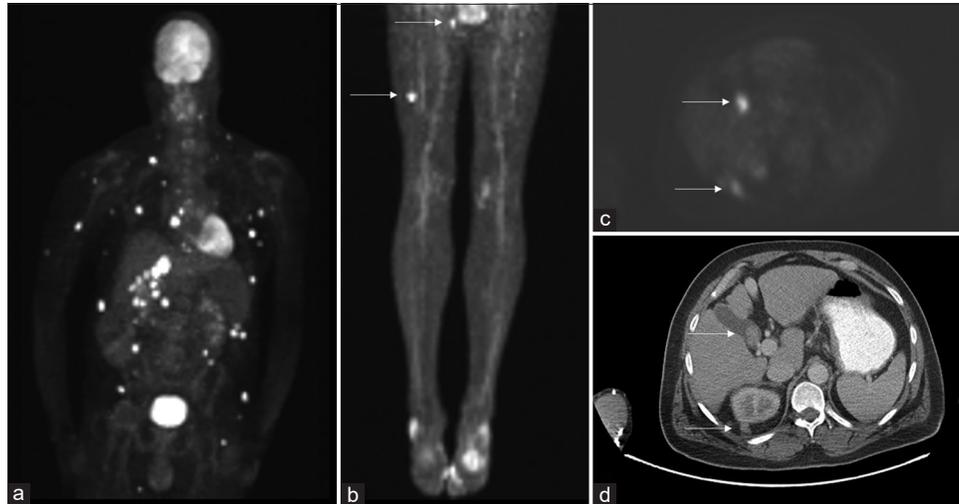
A 55-year-old male with primary melanoma site of the upper back. (a) Skull vertex to the upper thigh maximum intensity projection (MIP) image of ¹⁸F-fluorodeoxyglucose positron emission tomography/computed tomography (PET/CT) demonstrates diffuse metastatic disease. (b) Lower extremities MIP demonstrates two foci of increased uptake in the right thigh, consistent with metastatic disease (white arrows). (c) Axial attenuation corrected PET and (d) corresponding axial CT images demonstrates metastatic disease in the gallbladder and retroperitoneal region, posterior to the right kidney (white arrows).
